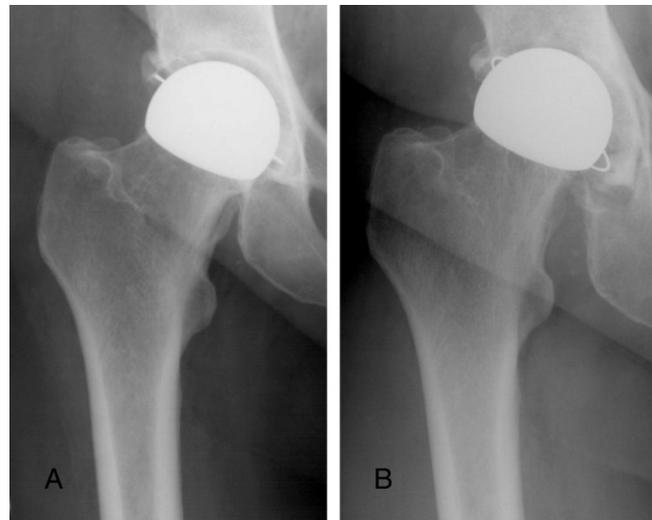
Picture showing a Patient treated with a RHA developed by Wagner, (A) postoperative anteroposterior radiography and (B) the same patient after 11,5 years (Picture from <http://www.arthroplastyjournal.org/article/S0883-5403%2809%2900109-0/fulltext>).
